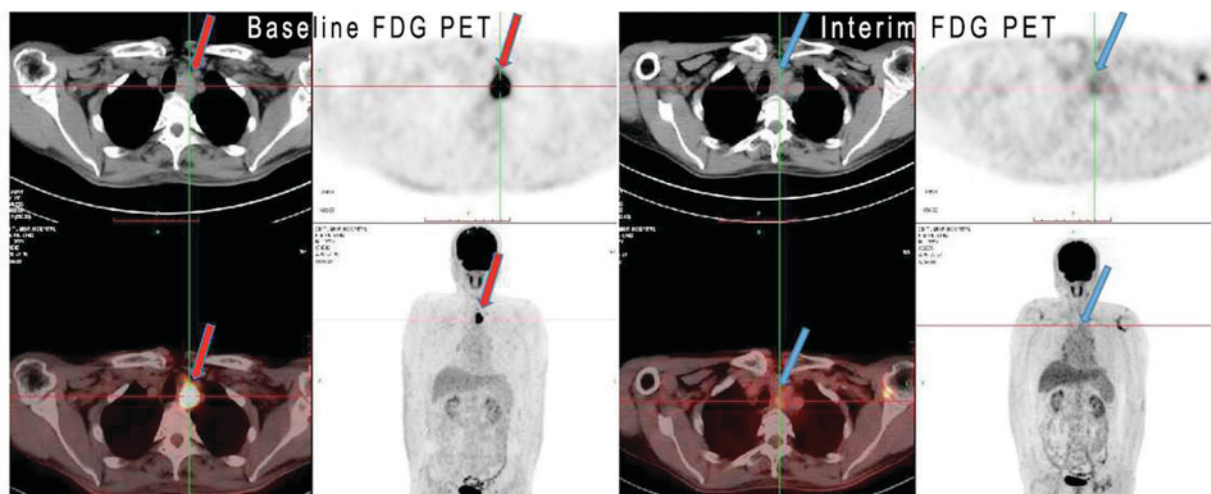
^{18}F -FDG PET scan of a 70-year-old male with upper thoracic esophageal squamous cell carcinoma. The red arrow indicates the primary tumor at the baseline ^{18}F -FDG PET scan. The SUV_{max} was 14.6 and the MTV was 19.2 cm^3 . The blue arrow indicates the primary tumor after 40 Gy/4 weeks of starting radiation therapy. The tumor FDG uptake had decreased to an SUV_{max} of 2.8 and an MTV of 4.1 cm^3 , with a final tumor partial response. ^{18}F -FDG PET, ^{18}F -fluorodeoxyglucose positron emission tomography; SUV_{max} , maximum standardized uptake value; MTV, metabolic tumor volume.
